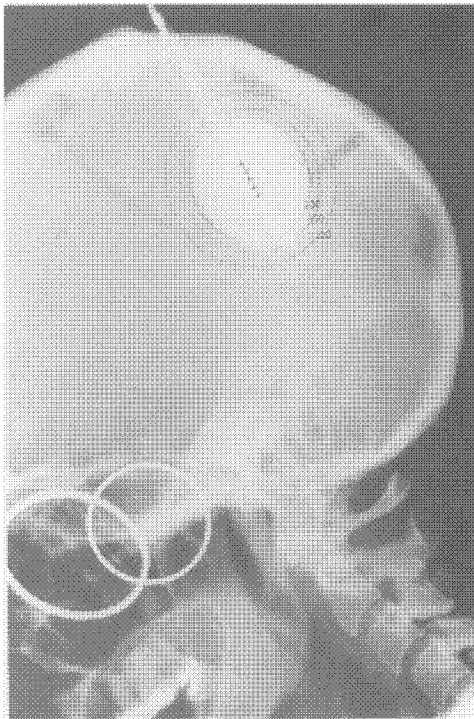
Lateral radiograph showing the double ring method of magnification calculation, and Isodose curves computed around a dummy source train in the balloon.
